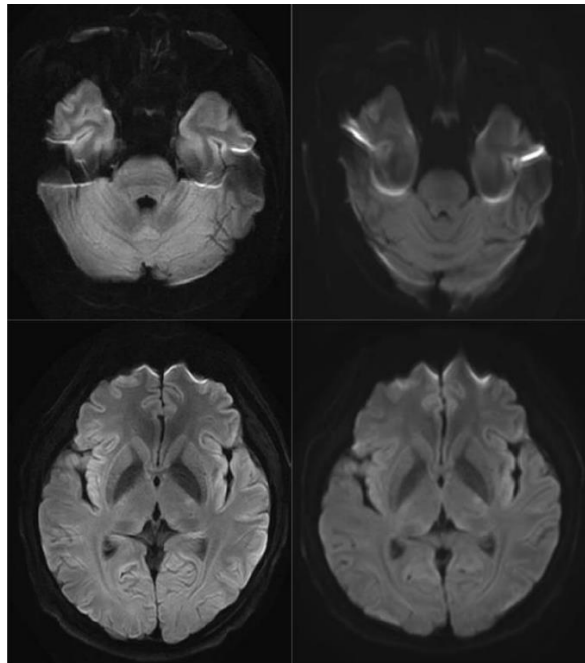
Reduced distortion caused by susceptibility artifacts in the frontal sinus and temporal bone regions in the 5T images compared to the 3T images. 2a, 2b: DWI images of the same participant. 2c, 2d: DWI images of the same participant. 2a, 2c were acquired using a 5T scanner, and 2b, 2d were acquired using a 3T scanner. The images show reduced distortion caused by susceptibility artifacts in the frontal sinus and temporal bone regions in the 5T images compared to the 3T images.
